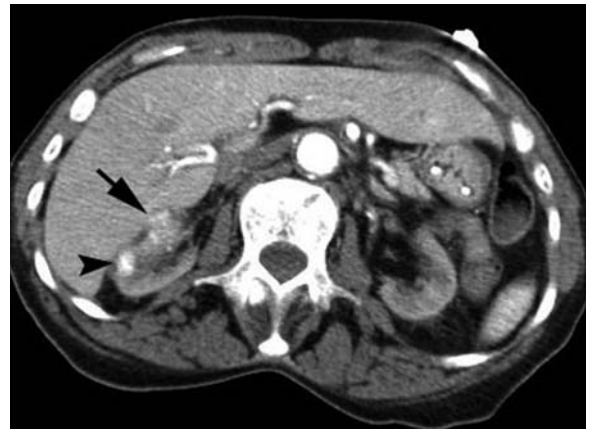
Conspicuous hypervascular masses in a 66-year-old woman with end-stage renal disease. Axial contrast-enhanced CT scan at early arterial phase shows renal atrophy bilaterally with poor cortical perfusion. An intensely enhancing 9 mm nodule is present in the right kidney (*arrowhead*) with a larger, but less enhancing, lesion anterior to it (*arrow*).
